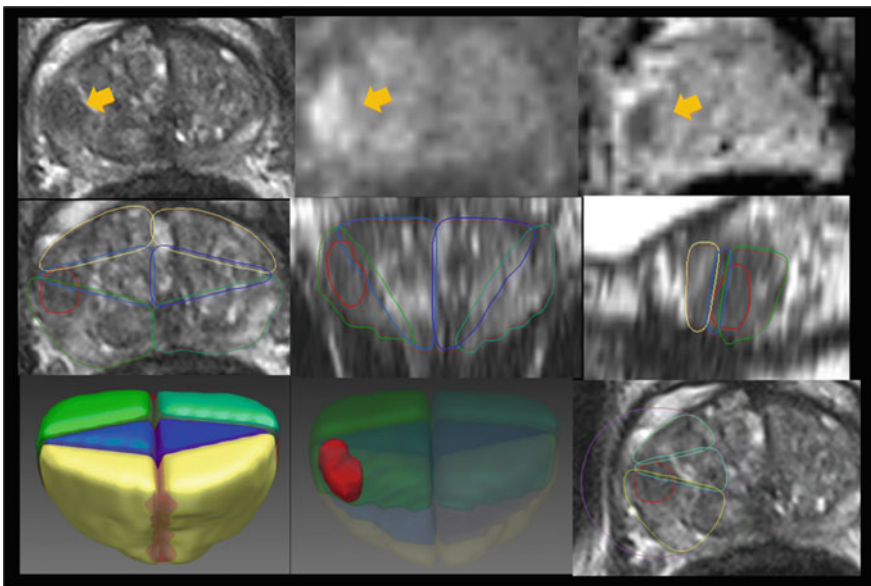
Multiparametric MRI of the prostate. Top panel: axial T2-weighted image (left), DWI $b = 1500 \text{ s/mm}^2$ image (middle) and ADC map (right) demonstrate a suspicious lesion (arrows) with marked signal increase on $b = 1500$, a markedly decreased ADC value and suspicious homogeneous hypointensity on the T2w image, PI-RADS 5. Middle panel: sextants are spatially defined for right and left anterior (yellow), middle (blue), and posterior (green) locations and shown together with the radiologically defined lesion (red) in axial (left), coronal (middle), and sagittal (right) planes. Bottom panel: volume renderings of the prostate segmentation seen from anteriorly superiorly with sextants shown (left) and lesion shown by decreasing the opacity of the sextant volumes (middle) © *European Radiology*, Bonekamp et al. (Epub ahead of print) [186]
